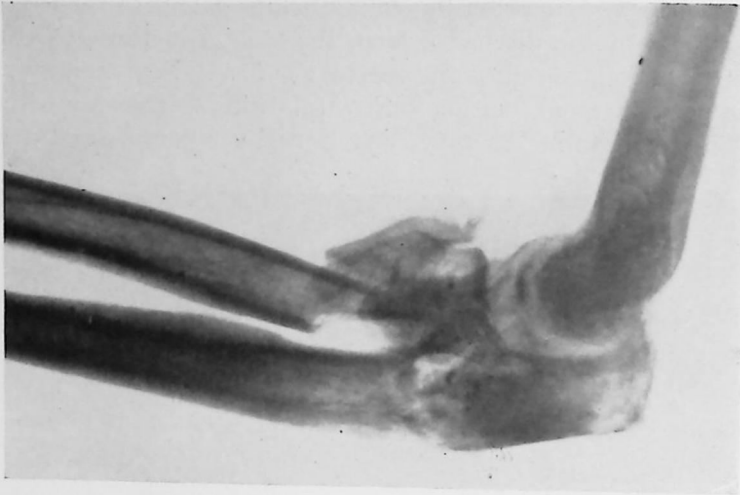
Lateral radiograph showing the same infected comminuted fracture of radius and ulna, after six weeks' treatment.
